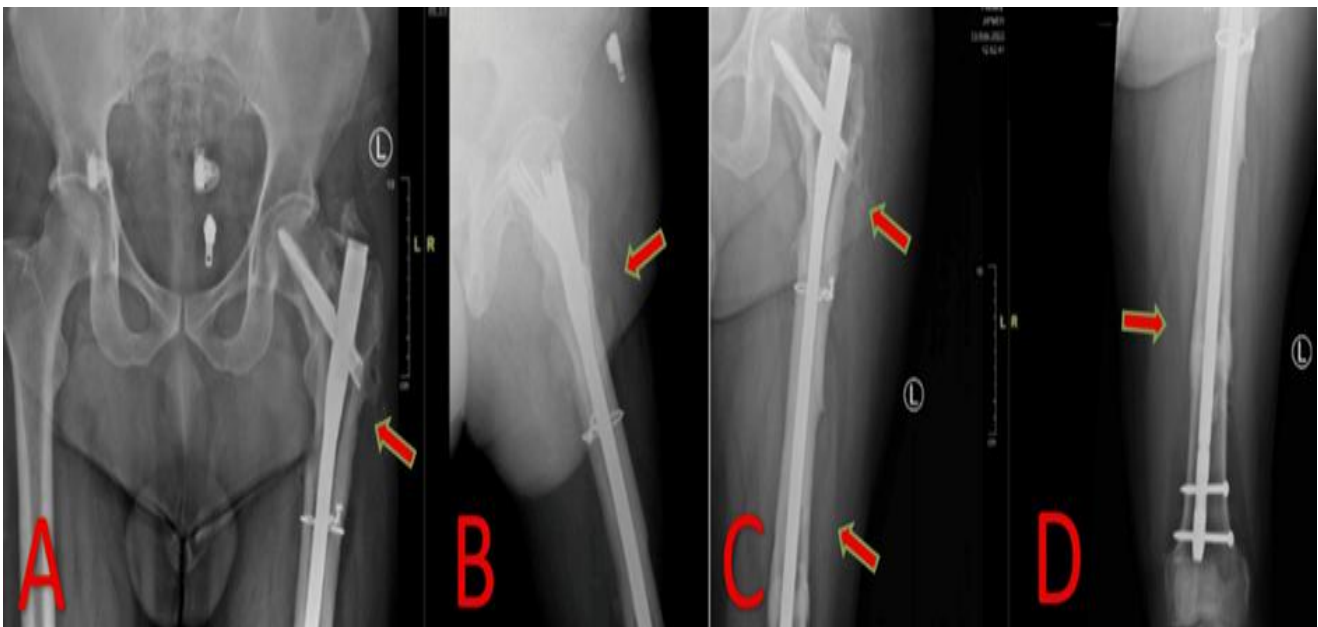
Anteroposterior and lateral radiographs of the left femur at two-year follow-up in case 2 showing complete union of the intertrochanteric and segmental shaft of femur fractures with maintained alignment and implant integrity. (A) Anteroposterior radiograph of pelvis with bilateral hip showing united left intertrochanteric femur fracture. (B) Lateral radiograph of left proximal femur showing united left intertrochanteric femur fracture. (C) Anteroposterior radiograph of left proximal thigh showing united left segmental shaft of femur. (D) Anteroposterior radiograph of left distal thigh showing united left segmental shaft of femur.
